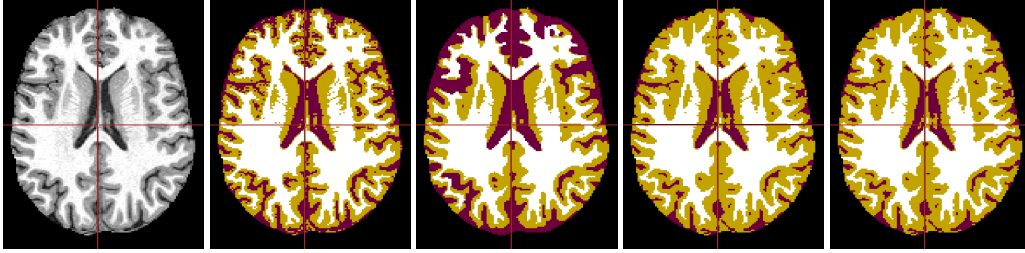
Hard tissue classifications obtained from a real MR image after 75 iterations. From left to right: raw slice, results of indep EM, ICM-EM, MF-EM, and VEM.
